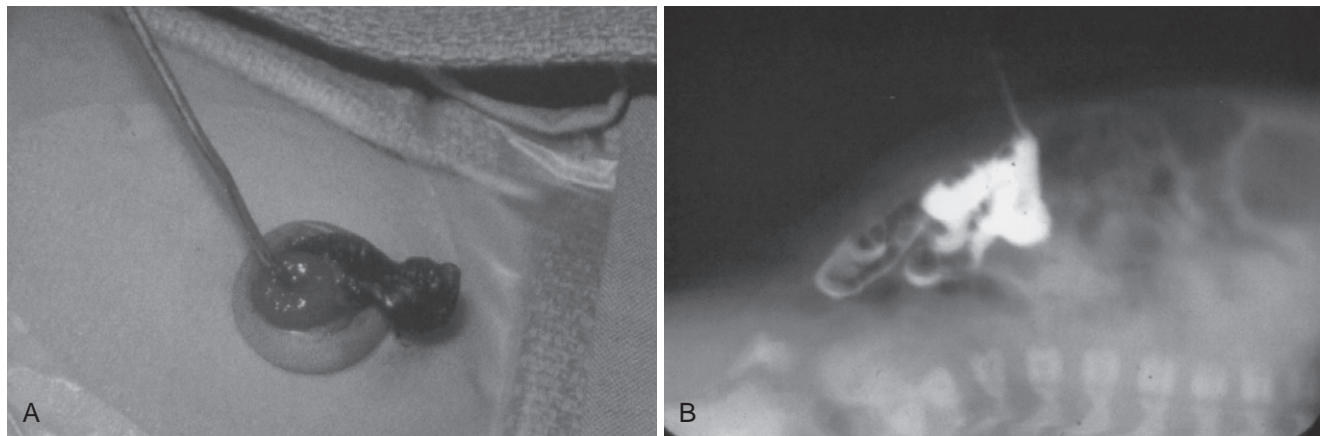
A, This photo of a newborn demonstrates probe patency of an omphalomesenteric duct into the ileum. B, A radiograph with contrast medium injected into a patent omphalomesenteric duct demonstrates filling of the small intestine. Studies of this sort are not usually necessary.
